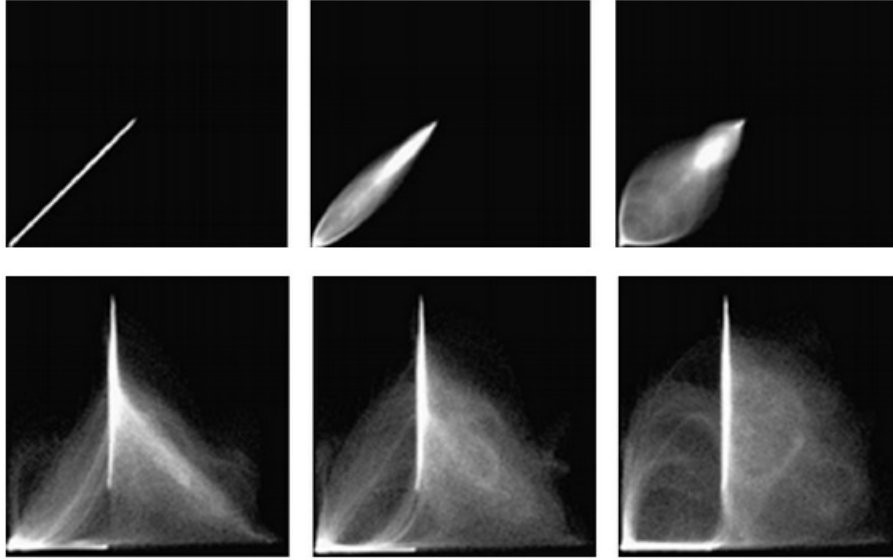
Joint histograms for the registration of identical MR images (top row) and CT to MR images (bottom row) of the head. On the left column, the images are aligned and towards right the misregistration increases. (Hill et al., 2001)
